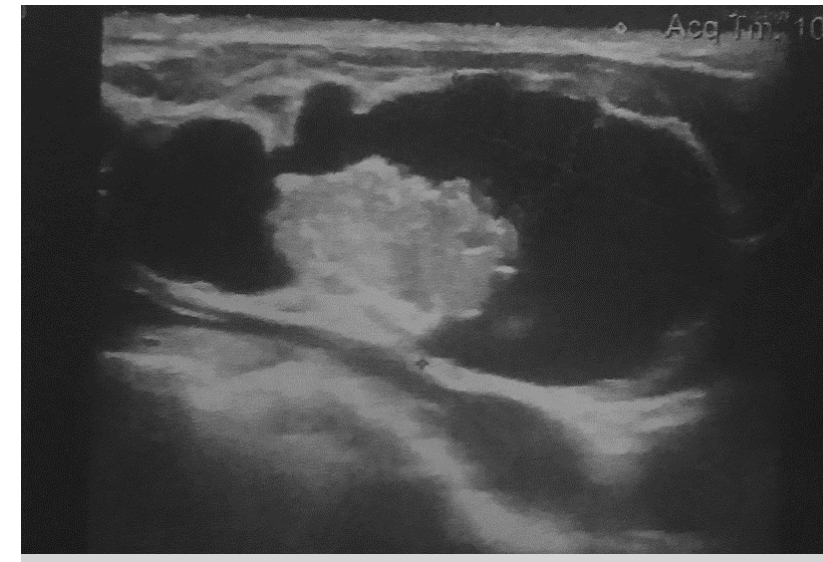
Cervical ultrasonography showing cervical cystic lymph node containing a vegetation that miming the thyroid gland "thyroid like"
